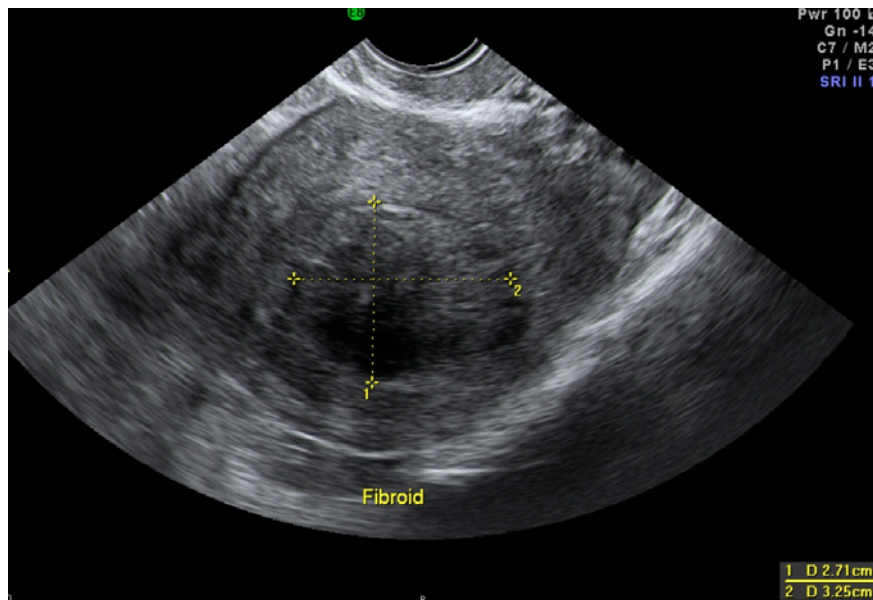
Transvaginal ultrasound showing submucous fibroid
